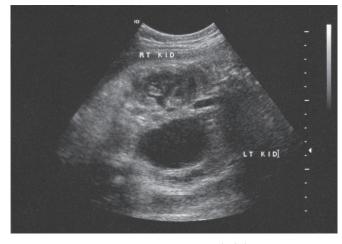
Ultrasound scan showing dilatation of left fetal renal pelvis.
